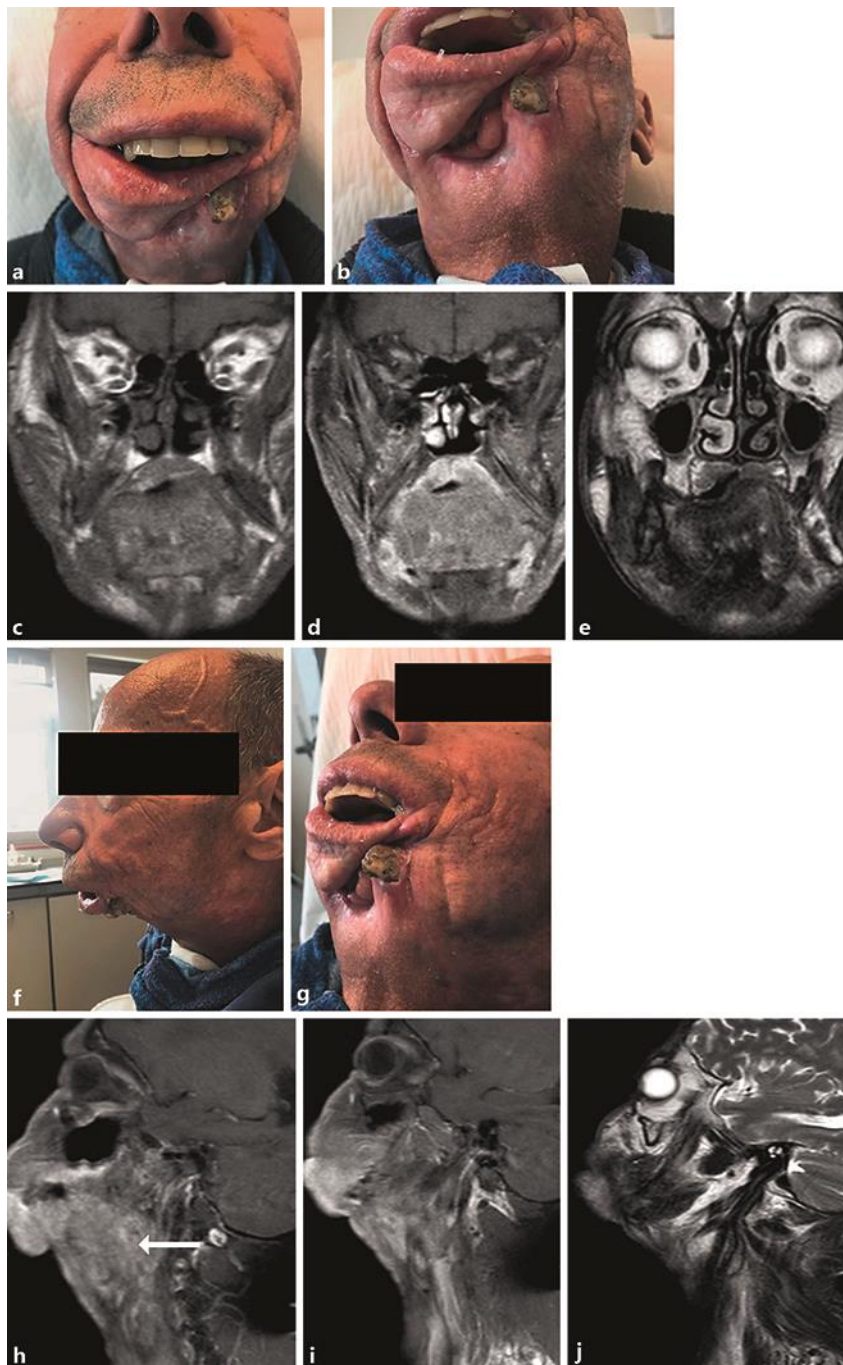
Patient photograph on the day the last evaluation with MRI was performed, in April 2018 (a, b, f, g). The patient presented clinical complete response; there was ongoing treatment with nivolumab, started on March 30, 2017. MRI revealed a diffuse-uptake area involving the anterior third of the tongue with extension to the soft tissues (c, d, e, i, j); the arrow in h points to a heterogeneity of the T2 signal, which is compatible with inflammatory changes; however, the presence of a tumor component could not be excluded; there was no suspicious involvement of oral mucosa, submucosa, and cervical lymph nodes. MRI, magnetic resonance imaging.
